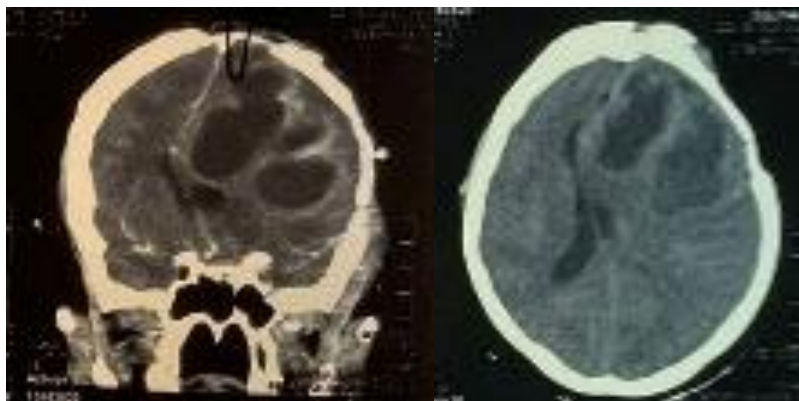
Head CT Scan with Contrast (a)coronal and (b) axial view
